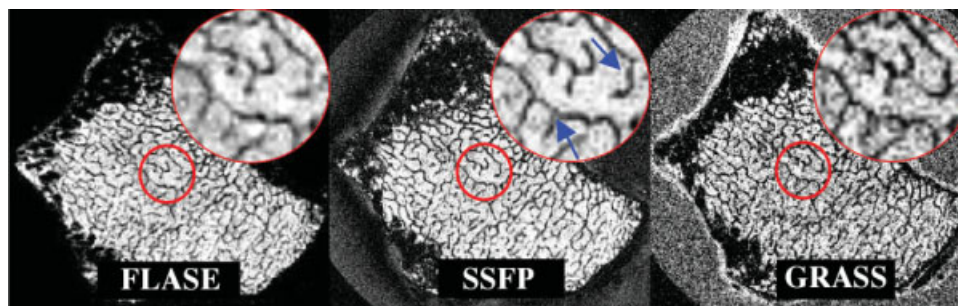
μ -MRI of intact distal radii obtained with different pulse sequences. Images were acquired in the same total scan time of approximately 17 minutes. Note that some trabecular elements that are not visible in the FLASE images are apparent in the SSFP and GRASS images (arrows).
